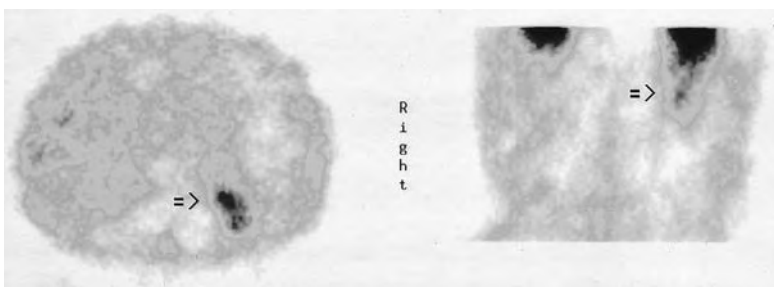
¹²³I-VIP receptor scintigraphy indicates the recurrent pancreatic tumor (arrow) 2 h after injection of 1 µg (150 MBq) radioligand (SPECT; left panel: transverse reconstruction; right panel: coronal reconstruction)
